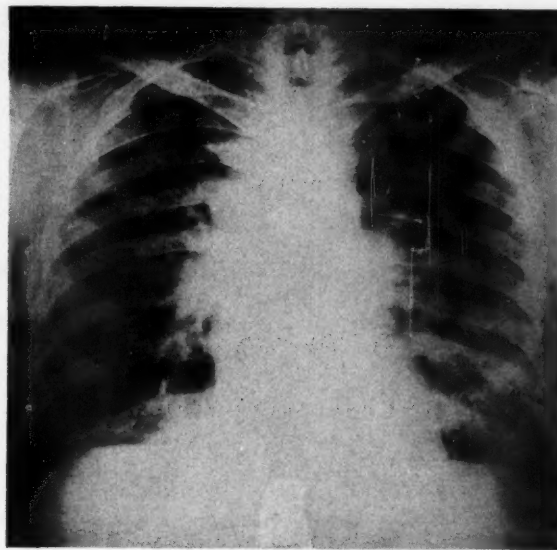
Case VIII. Roentgenogram of chest; full inspiration.
